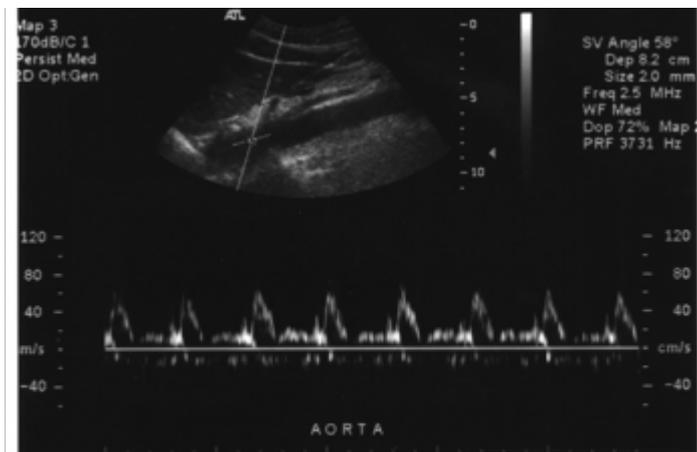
B-mode image and PW Doppler spectral waveforms
